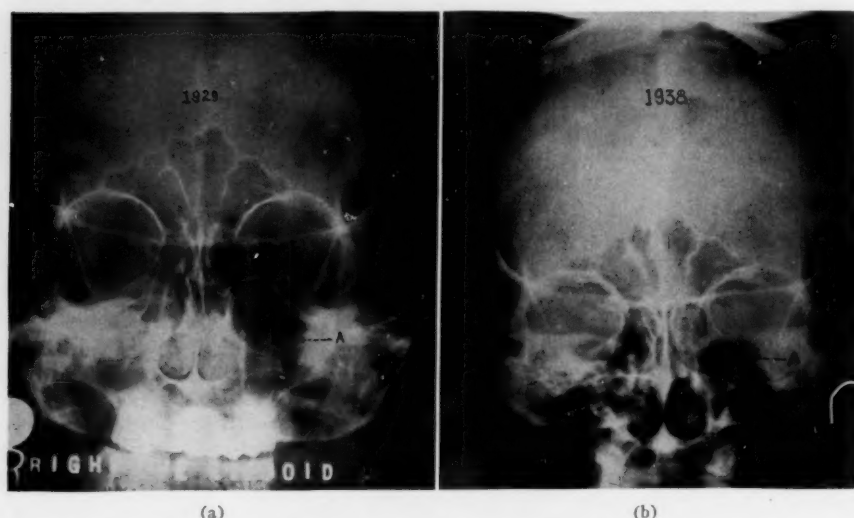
(a).—Case 5: Roentgenogram, made in 1929, showing destruction of petrous tip (A) by erosion of epidermoid of middle fossa. (b) Destruction of petrous (A) only slightly increased after nine years; roentgenogram made in 1938.
